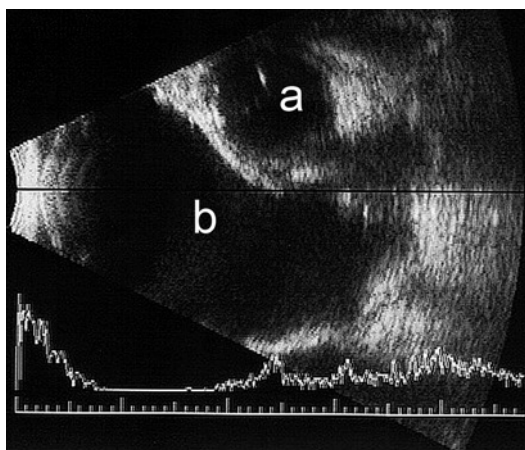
Ultrasound scans of an orbit with a microphthalmic eye with cyst. The small eye (a) is seen above the large cyst (b)
